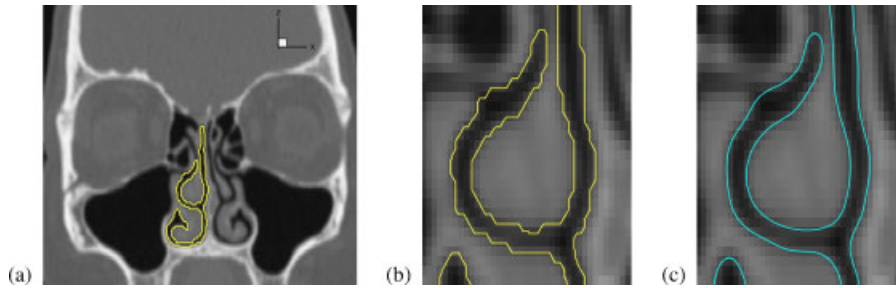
(a) CT image projected in the coronal plane, corresponding to slice MC (middle cavity), with user-defined segmentation. Note that the sinuses and secondary conduits are excluded. Detail of the middle meatus section with (b) step-like segmentation as selected by the user and (c) reduced model (using 15 dominant Fourier modes).
